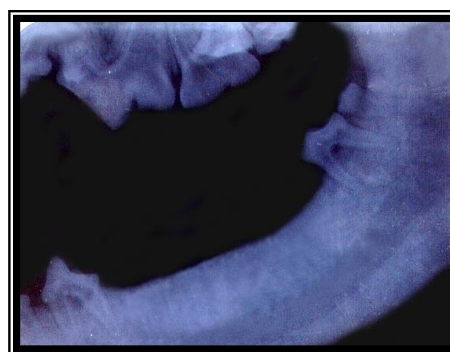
Radiographic view of the lower jaw showing bone healing two months post extraction period.
